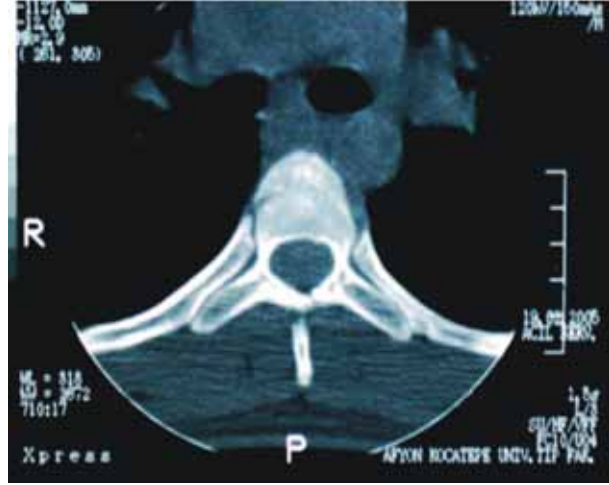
Computerized tomography (CT) scan: the wedge fracture in the anterior column and lamina fracture in the posterior column (T5 vertebrae).
